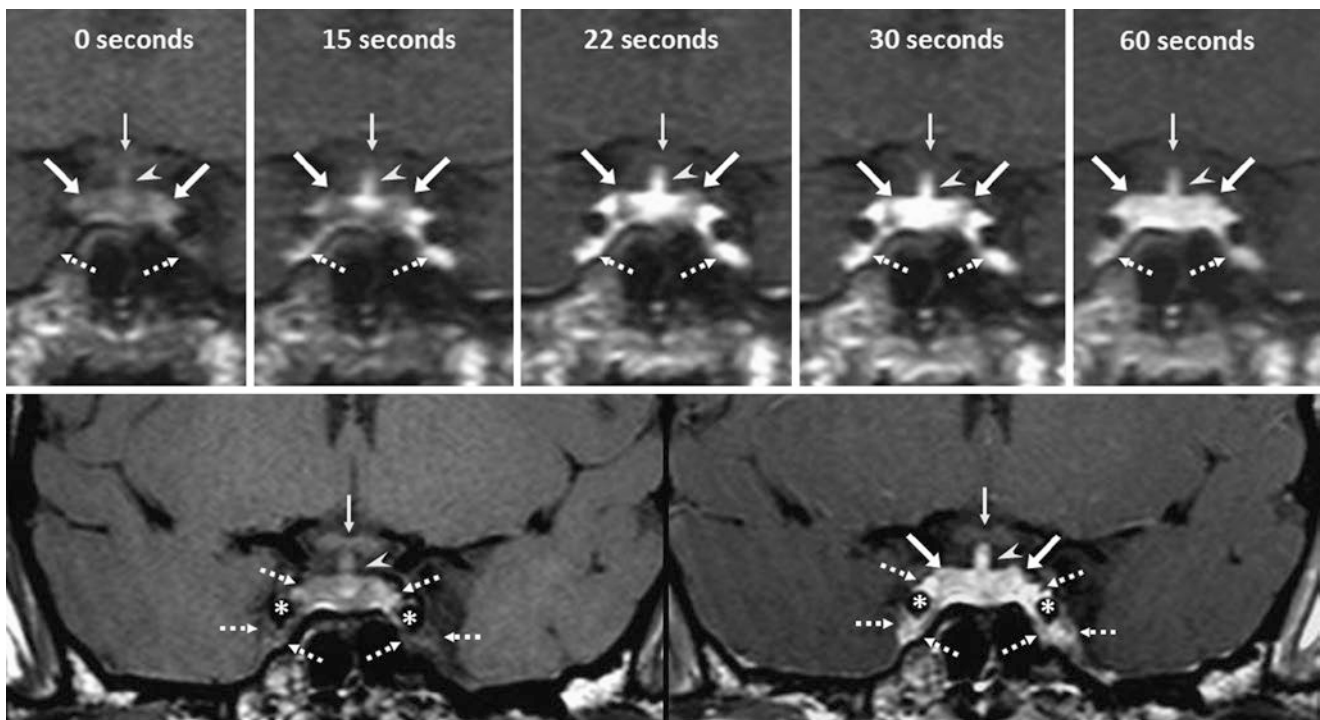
Normal dynamic enhancement of the pituitary extending laterally. The patient was a 21-year-old female with hypopituitarism. On a 3 T MRI (interpreted as normal), dynamic contrast enhanced T1WIs (top row) from time 0 (noncontrast) to 60 s, the lateral aspects of the anterior lobes (arrows) filled with contrast more slowly than the stalk
